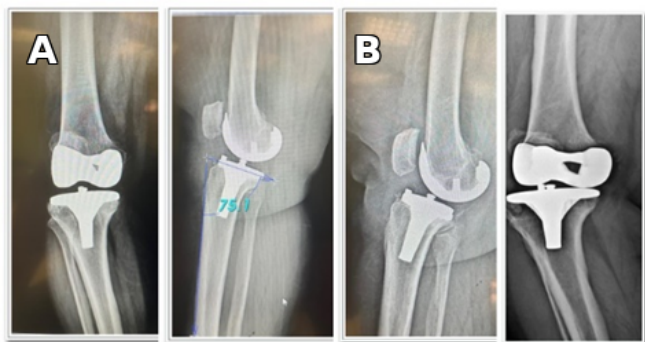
Early and late postoperative radiographs of the patient. (A) Six-month postoperative radiograph demonstrating initial implant positioning. (B) Eight-year postoperative radiograph showing varus malalignment and increased posterior tibial slope (arrows), suggesting abnormal load distribution contributing to tibial post failure.
